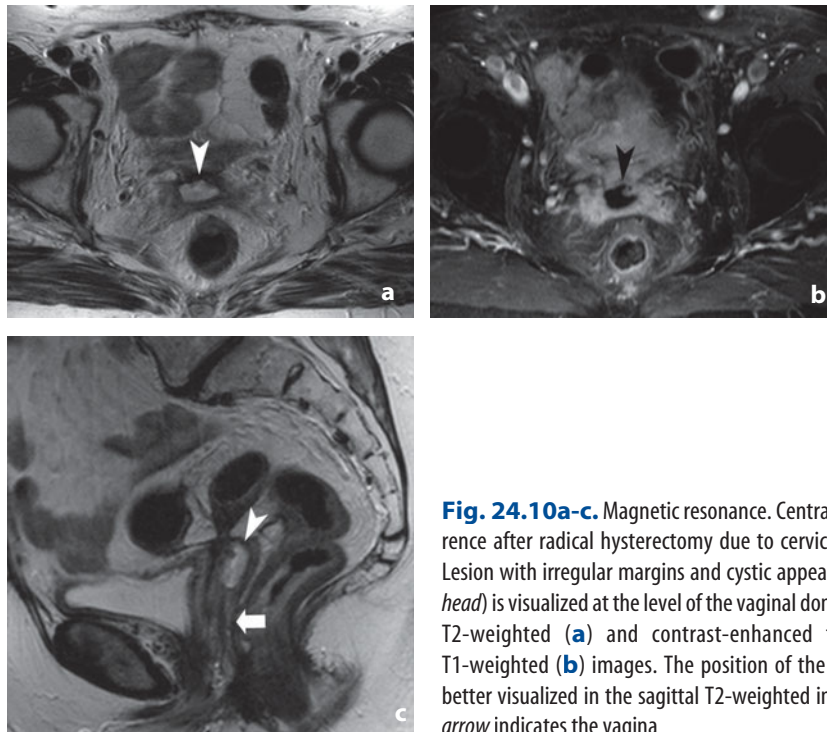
Magnetic resonance. Central pelvic recurrence after radical hysterectomy due to cervical carcinoma. Lesion with irregular margins and cystic appearance (*arrowhead*) is visualized at the level of the vaginal dome in the axial T2-weighted (a) and contrast-enhanced fat-saturated T1-weighted (b) images. The position of the recurrence is better visualized in the sagittal T2-weighted image (c). The *arrow* indicates the vagina
